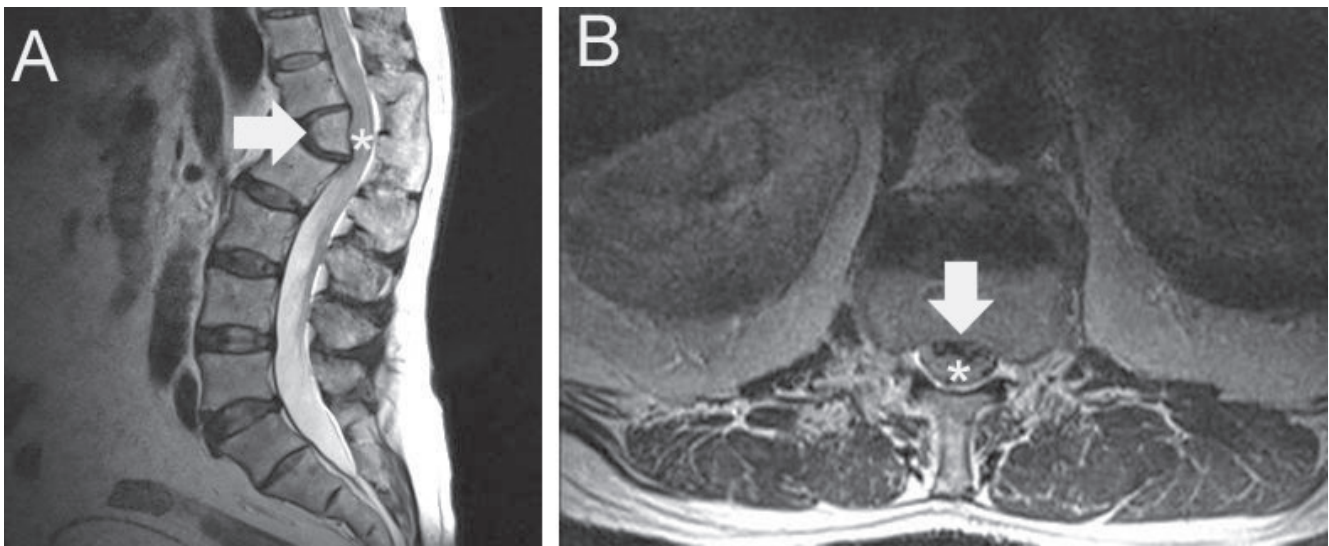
A T2 weighted sagittal (A) and axial (B) magnetic resonance images revealed L1 hemivertebra (arrow) compression to the thecal sac and spinal cord (asterisk).
